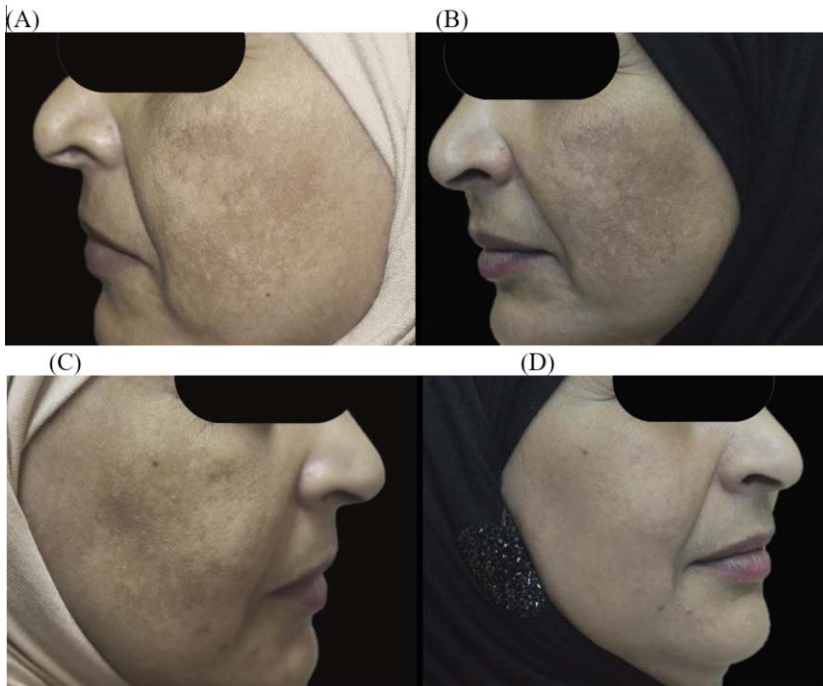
A subject with malar melasma. (A) Baseline side before treated. (B) Control side before treated. (C) HIFU+laser treated. (D) Treated with laser alone. HIFU: High-intensity focussed ultrasound.
